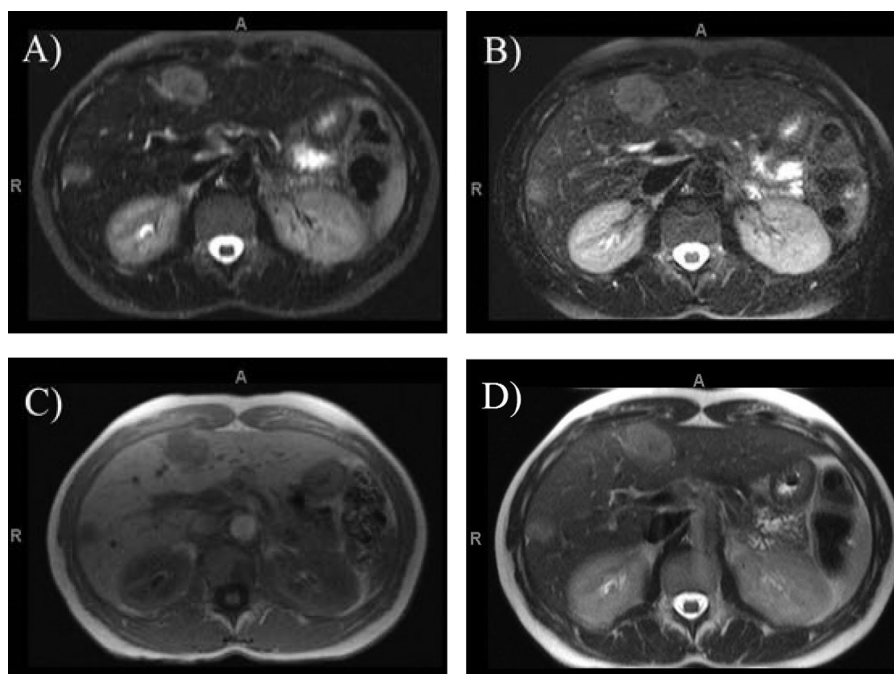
Subset of possible MR image sets. (A) STIR, (B) TSE T2, (C) in and opposed phase, and (D) HASTE.
